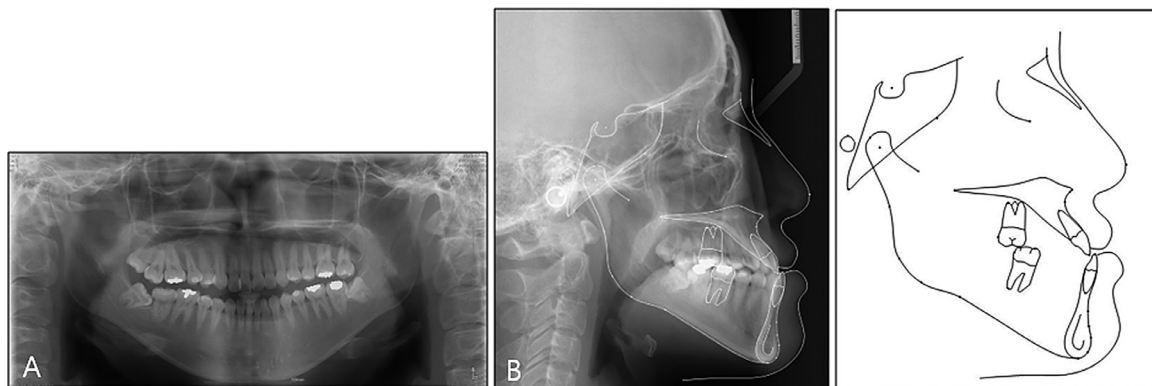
(A) Pretreatment panoramic radiograph. (B and C) Cephalometric tracing using V-ceph software (CyberMed, Inc., Seoul, Korea).
